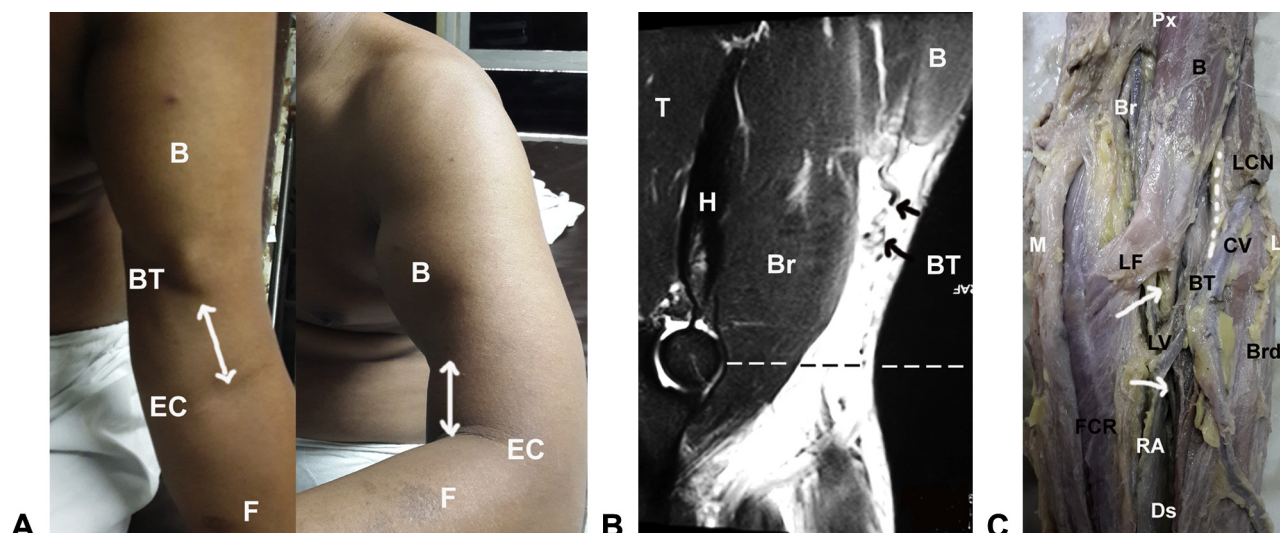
A A retracted DBT tear presents as a bulge (B) in the left upper arm, and a depression (arrows) in the lower aspect of the arm. The retracted tendon (BT) can be visualized in the arm. EC, elbow crease; F, forearm. B Magnetic resonance imaging shows severe retraction of the BT. The EC (dotted line) is shown for reference. Br, brachialis; H, humerus; T, triceps. C Surgical anatomy of the left elbow distal BT and cubital fossa is shown. The distal BT passes dorsal (arrows) to the leash of vessels (LV) formed by branches of radial vessels (RA) that supply the brachioradialis (Brd). B, biceps muscle; Br, brachial vessels; CV, cephalic vein; Ds, distal; FCR, flexor carpi radialis; L, lateral; LCN and dotted line, lateral cutaneous nerve; LF, lacertus fibrosus; M, medial; Px, proximal; RA, radial artery.
